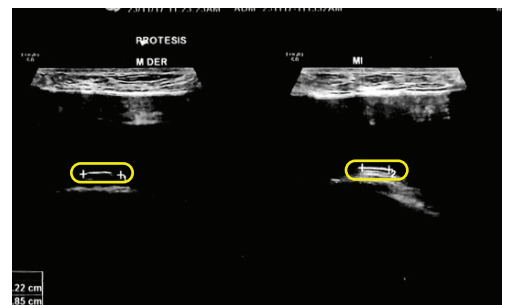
Breast ultrasound showing the RFID in both right and left implants.
